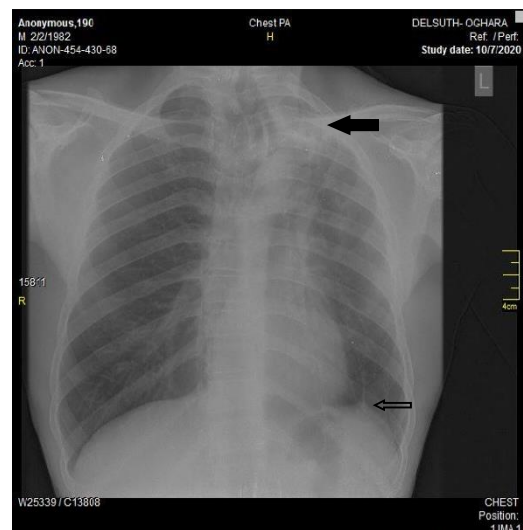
Posteroanterior chest radiograph of a 38-year old HIV sero-negative PTB patient showing left upper lobe volume reduction from fibrosis (black arrow), with ipsilateral tracheal deviation. There is tenting of the left hemidiaphragmatic outline caused by fibrotic strands (white arrow).
